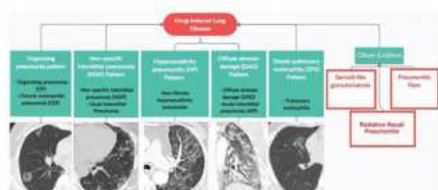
Radiological findings of drug-induced lung disease during chest computed tomography.
